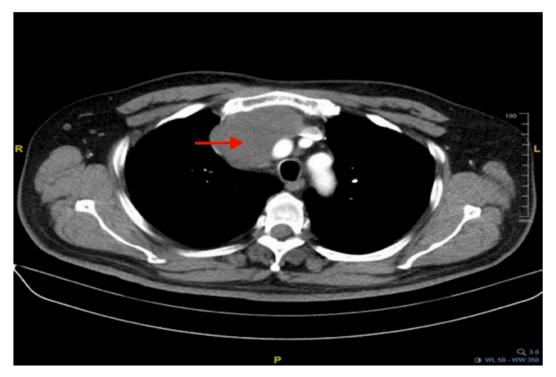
Chest CT scan image demonstrating the soft tissue mass of the anterior superior mediastinum (measuring $68 \times 62 \times 54$ mm).
